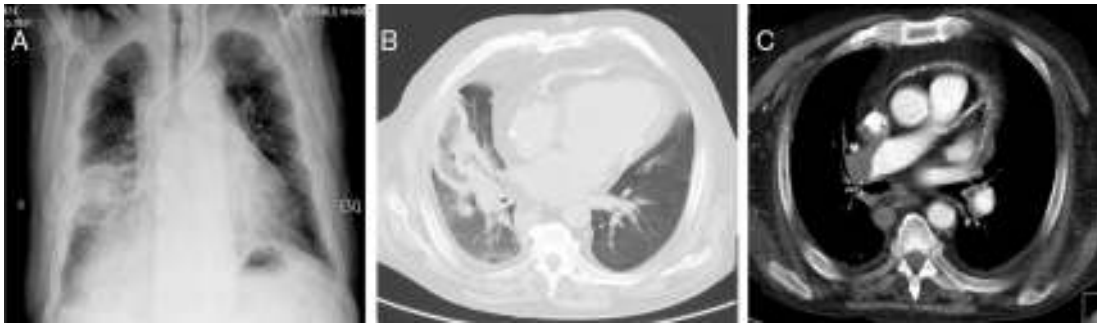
(A) Chest X-ray showing a roughly nodular opacity in the right perihilar region; (B) Chest CT showing the reversed halo sign; (C) CT pulmonary angiography showing the presence of a thrombus in the right main pulmonary artery.
